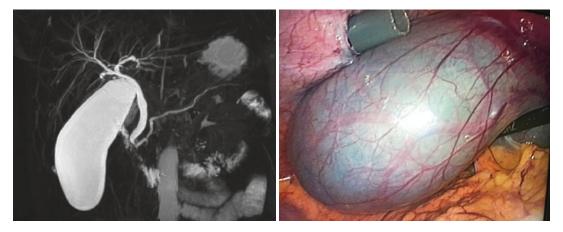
Noninfectious gallbladder hydrops (13 cm) due to stenosis of the terminal common bile duct induced by autoimmune pancreatitis (MRI imaging and intraoperative aspect during laparoscopic cholecystectomy) in a
